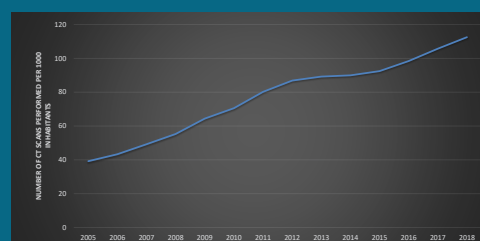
Changes in mean number of CT scans per 1000 inhabitants living in the North Denmark Region from 2005 to 2018.
